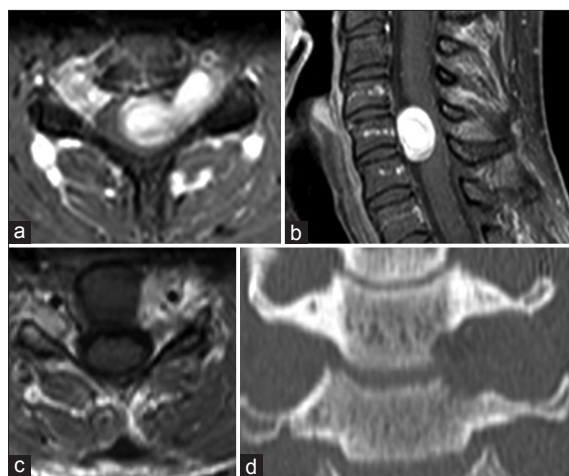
Preoperative axial (a) and sagittal (b) MRI with contrast showing a predominantly intradural tumor component; postoperative MRI (c) (T1 with Gadolinium) showing a gross total resection through the expanded C5 foramen; coronal CT (d) showing the expanded C5 foramen (patient 1)
